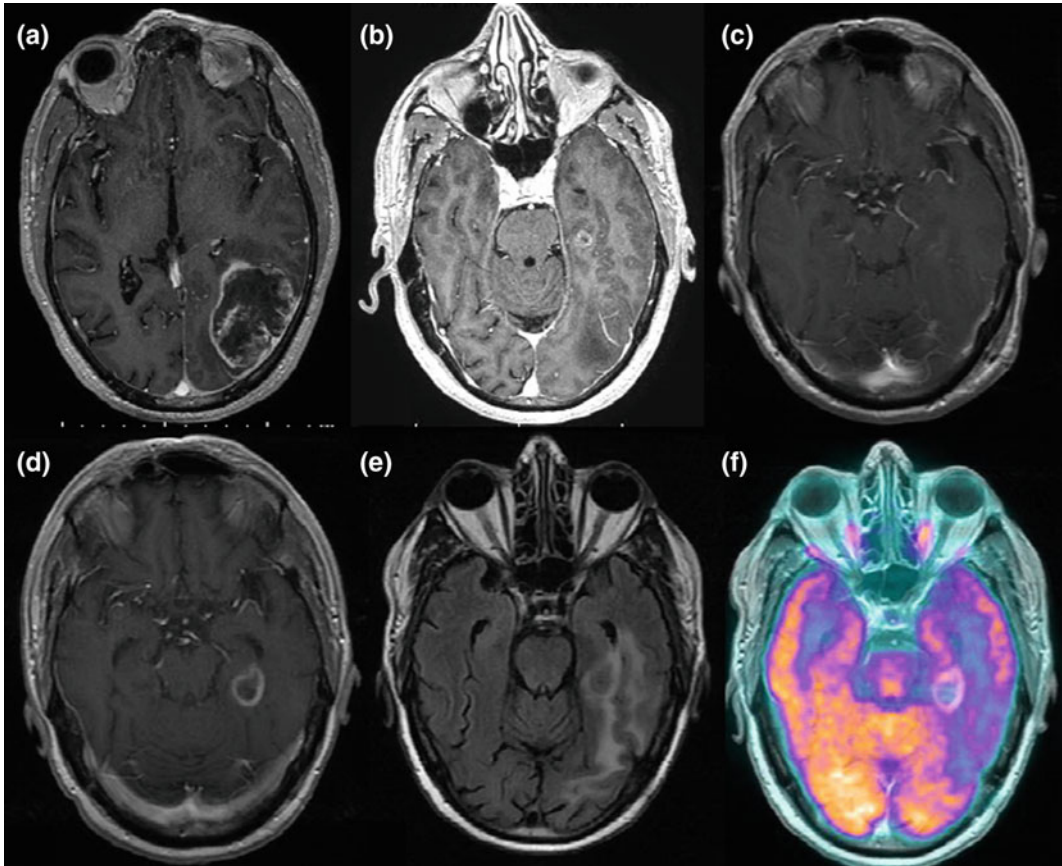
Response to LITT in a 50-year-old male patient diagnosed with a multifocal GBM and treated with partial surgical resection of a larger GBM focus, followed by laser ablation of all GBM foci. a T1-weighted Gadolinium sequence showing a large left occipital GBM focus that was resected and treated by 54 Gy of fractionated radiation;
